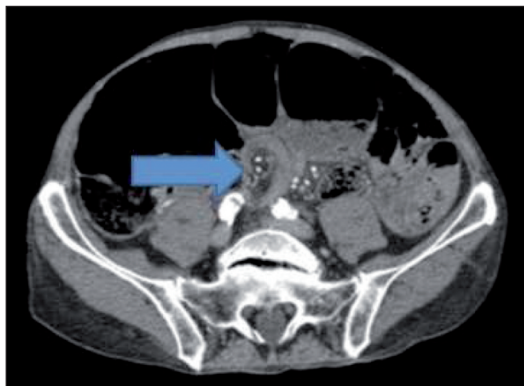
Axial computed tomography image with intravenous contrast material demonstrating flat intestinal loops encircle vessels.
